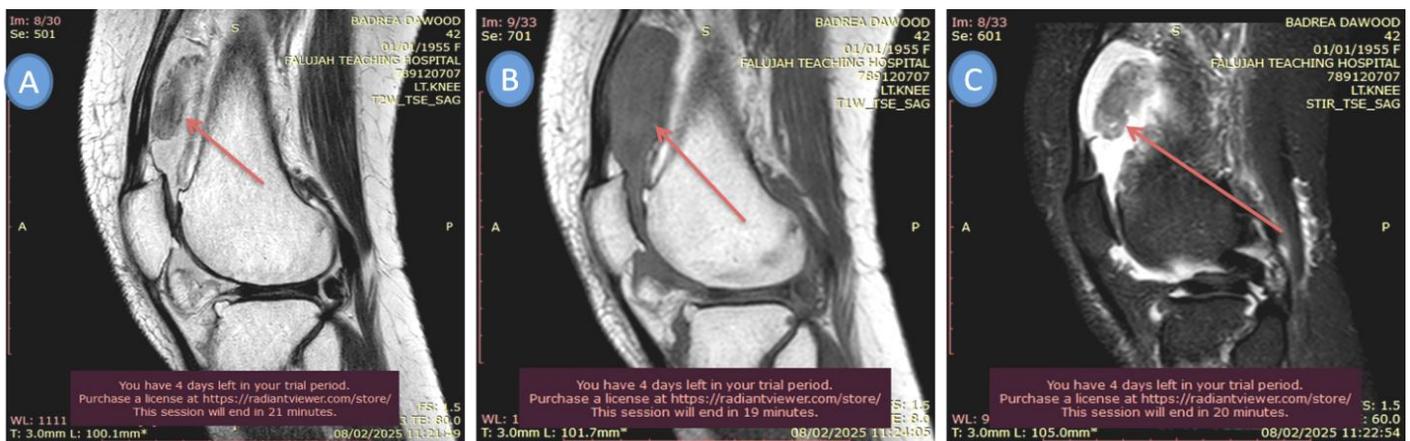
A: T2w sagittal, B: T1w sagittal, C: STIR sagittal, MRI Knee of a patient showing lesion Surrounding swelling is noted (arrow).
